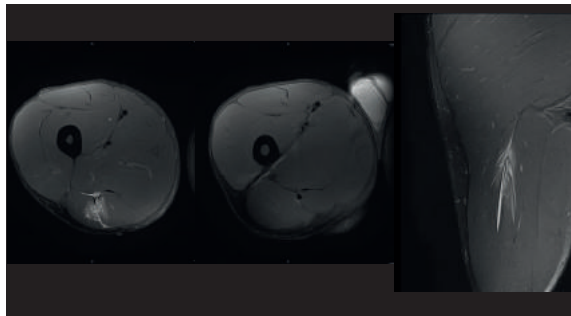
(Case #2). MTJ of the central tendon of the long head of the biceps and in semitendinosus muscle. MRI signs include peritendinous oedema, peripheral and partial disruption of the tendon, intermuscular fluid and intramuscular haemorrhage, and a very slight loss of tension in the semitendinosus tendon.
